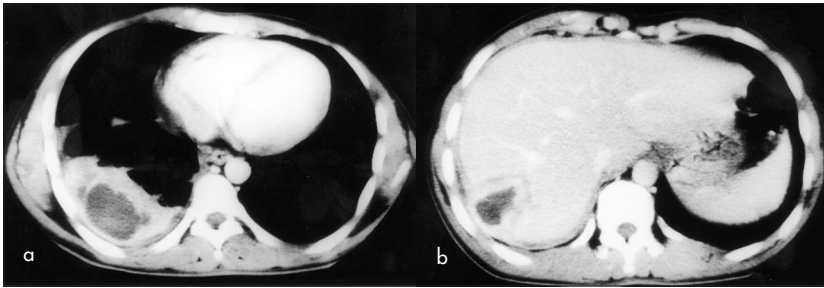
Computed tomography scan of (a) the chest and (b) abdomen showing consolidated lung with an effusion that communicated directly with an abscess in the right lobe of liver.
